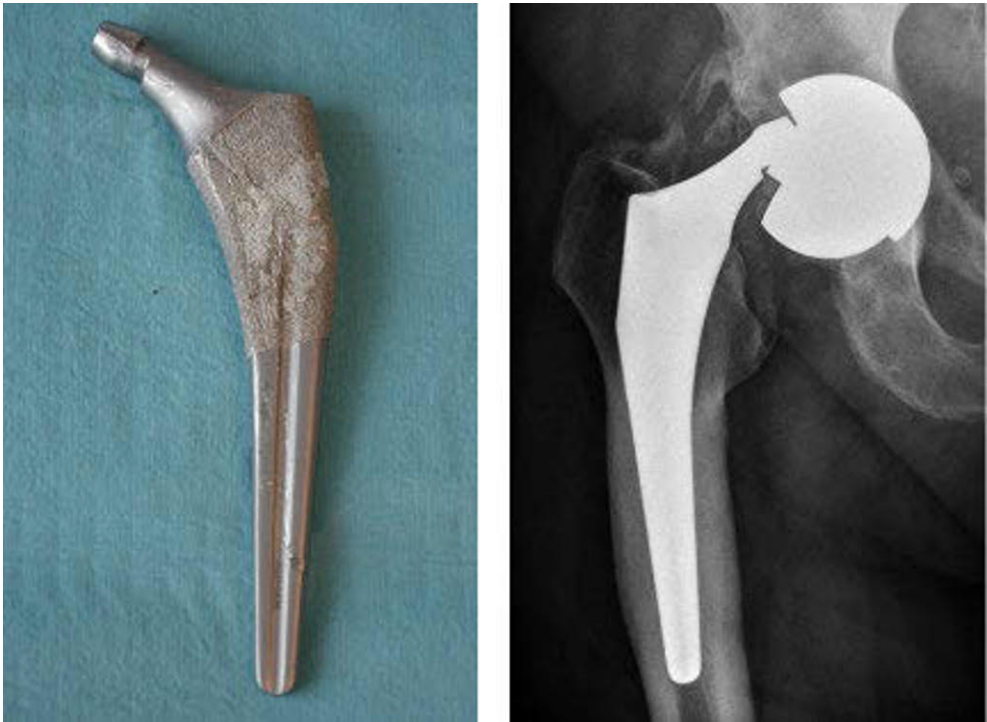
Severely damaged trunnion and “bird beak” appearance of an Accolade stem (left). Anteroposterior radiograph showing the femoral head dissociated from the trunnion after THA (right).
